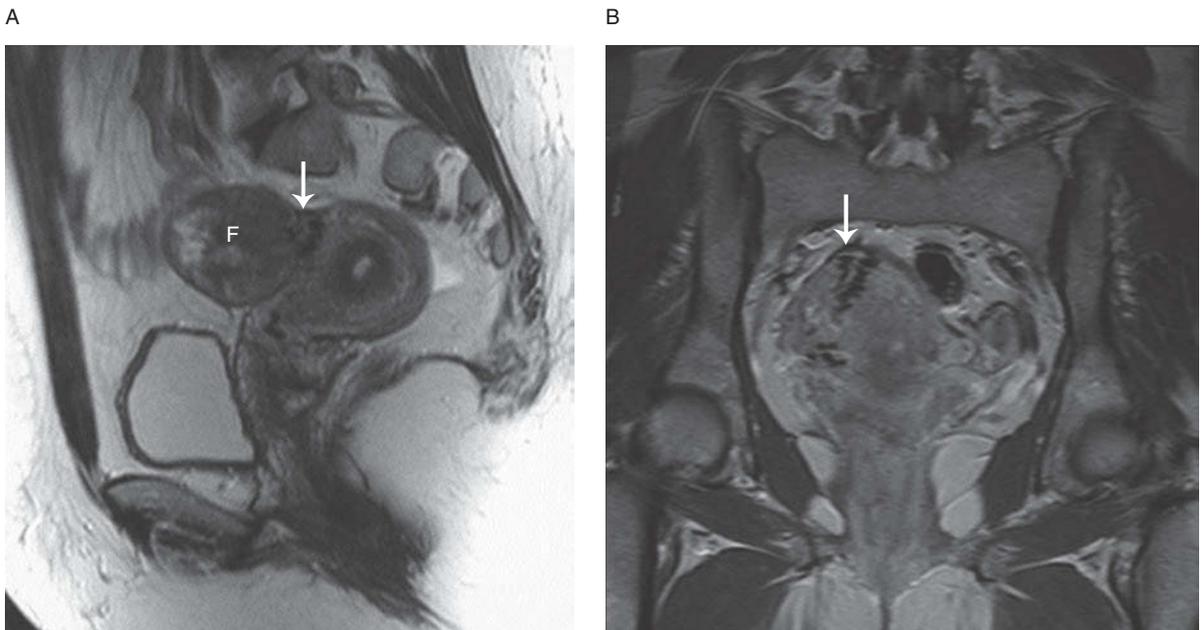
Exophytic fibroid in a 45-year-old female. Sagittal T2-weighted image (A) demonstrates the neck (arrow) between an exophytic fibroid (F) and uterus. Better demonstrated on a corresponding coronal T2-weighted image (B) are bridging low signal intensity vessels (arrow) between the uterus and fibroid.
